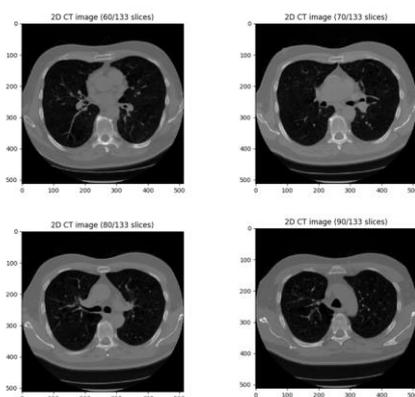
Examples of lung CT scan images in DSB dataset
